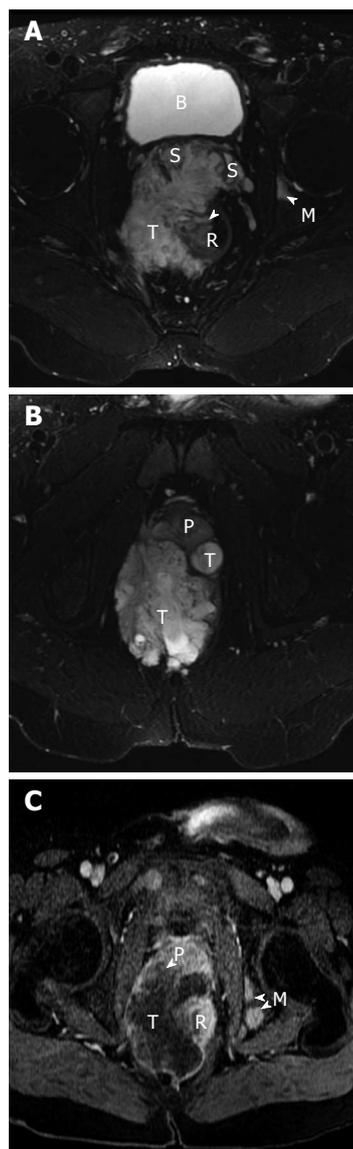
Magnetic resonance images of the patient. A and B show the axial T2-weighted fat suppressed MR images of the pelvis. A heterogeneous but predominantly high signal intensity tumor mass (T) is seen arising from the right lateral wall (arrow) of the rectum (R). This mass extends anteriorly to invade both seminal vesicles (S) and abuts and displaces the prostate gland (P). A high signal focus in the left acetabulum represents a bone metastasis (M). The bladder is noted as B. C is the MR image about 5 wk later, now repeated with contrast. T1-weighted post-contrast fat saturation MR image correlating to image in Figure 2b shows rim enhancement of the mass with a large central low signal area consistent with central necrosis. There is now invasion of the tumor into the prostate gland (P) and multiple new osseous metastases (M).
